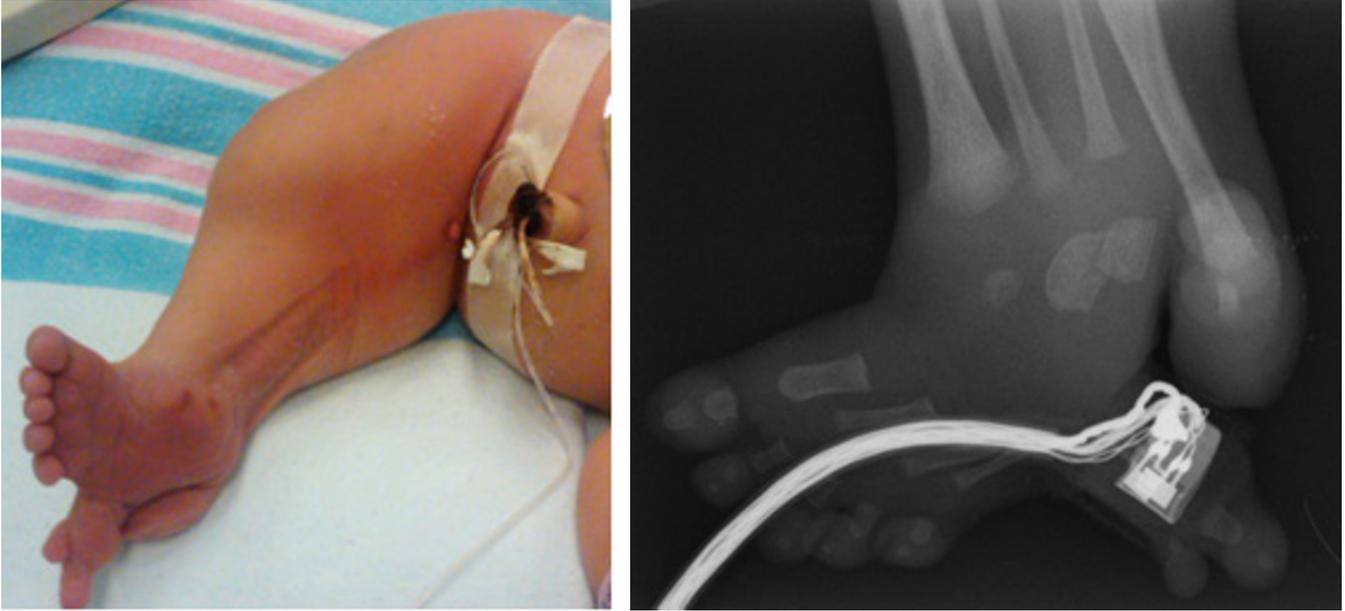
Infant female with sirenomelia. Postpartum photo (left) and radiograph (right) demonstrate fused and abnormally positioned legs with flipper/mermaid deformity.
